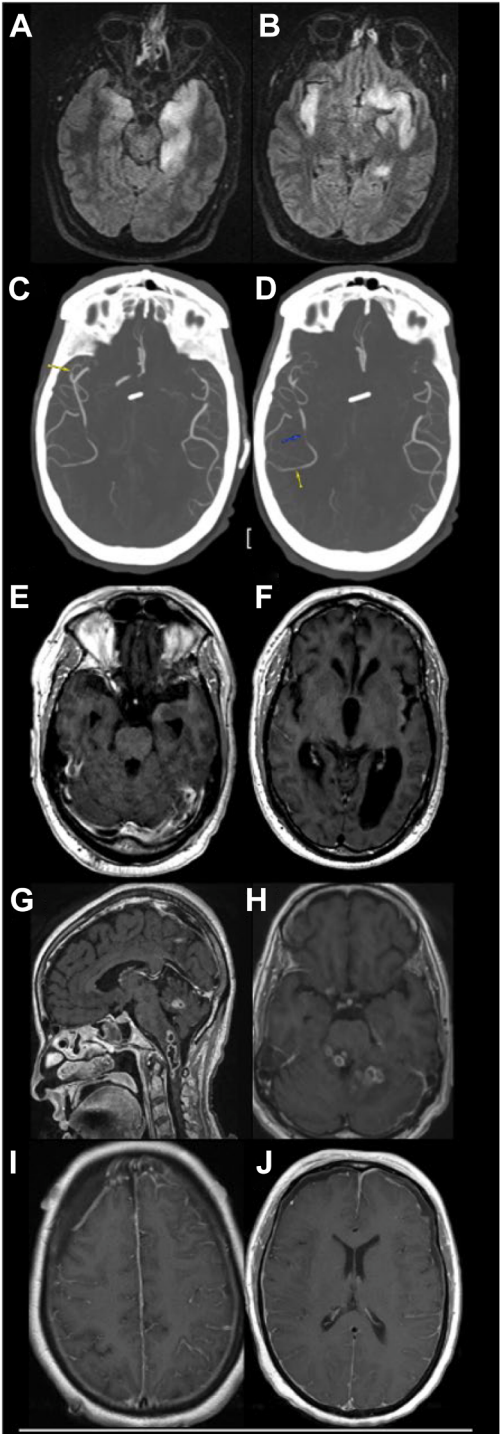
Neuroradiology findings of meningitis and encephalitis caused by various pathogens. (A–B) T2 FLAIR hyperintensities of the L medial temporal lobe and the bilateral insula in HSV
